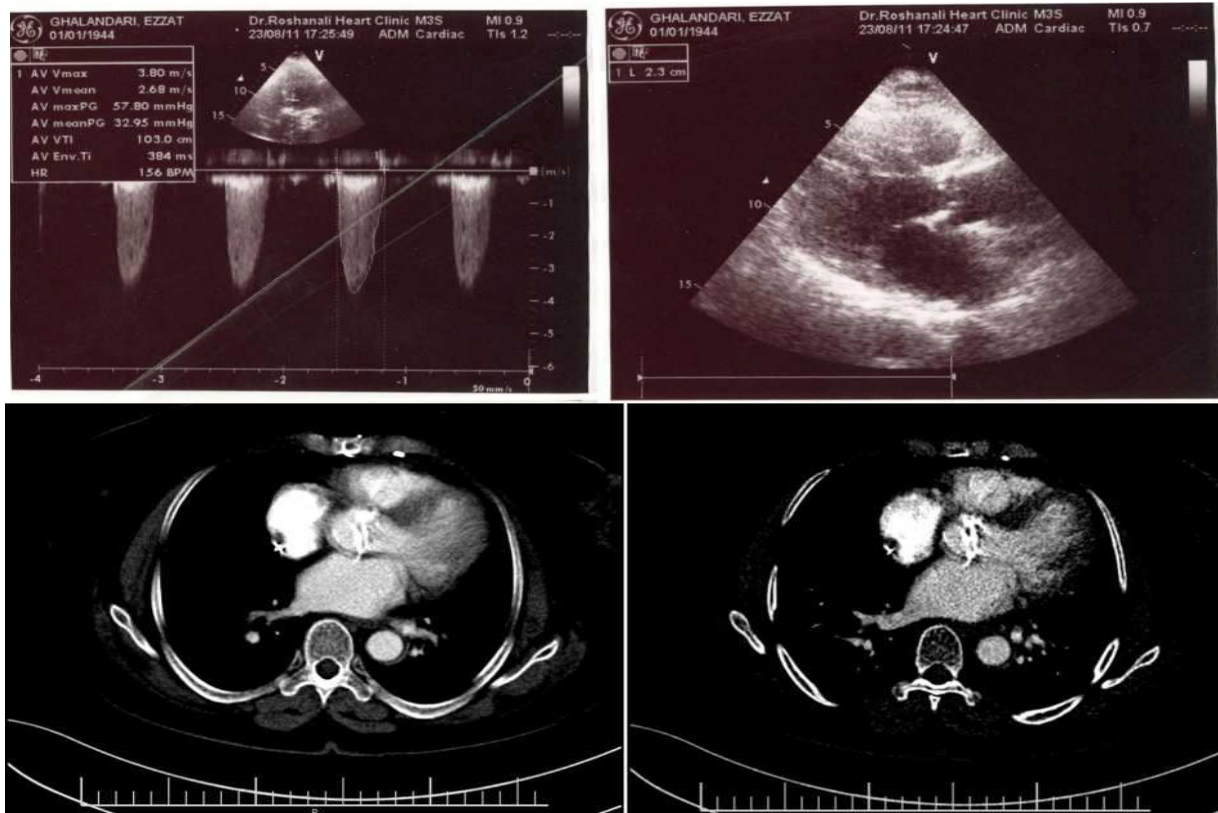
Echocardiography and computed tomography angiography of the patient showing a bicuspid aortic valve with a peak pressure gradient of 57.8 mm Hg
